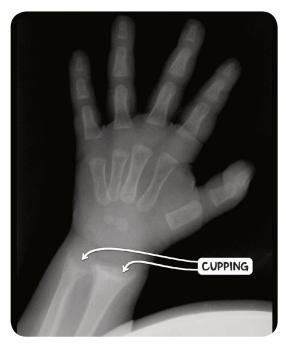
An X-ray image of the wrist demonstrating metaphyseal cupping, also known as metaphyseal flaring, in an individual with rickets.
